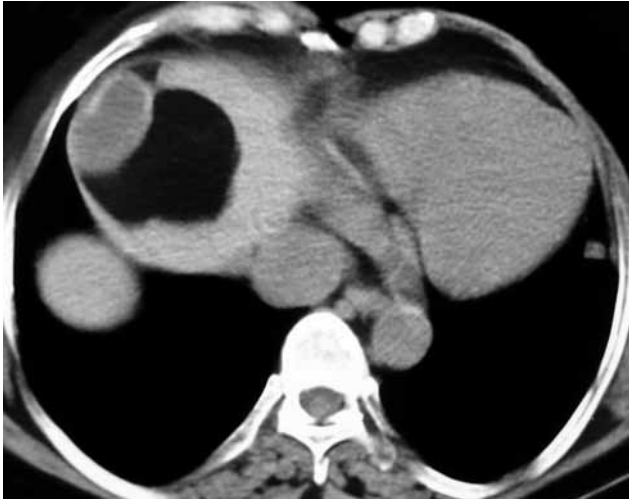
Computed tomographic image of the first case showing the homogeneous, smooth-bordered cystic lesion at the lateral portion of the diaphragm. Separation from the liver border at the localization was achieved correspondent to the anterior basal segment of the lower right lung.
